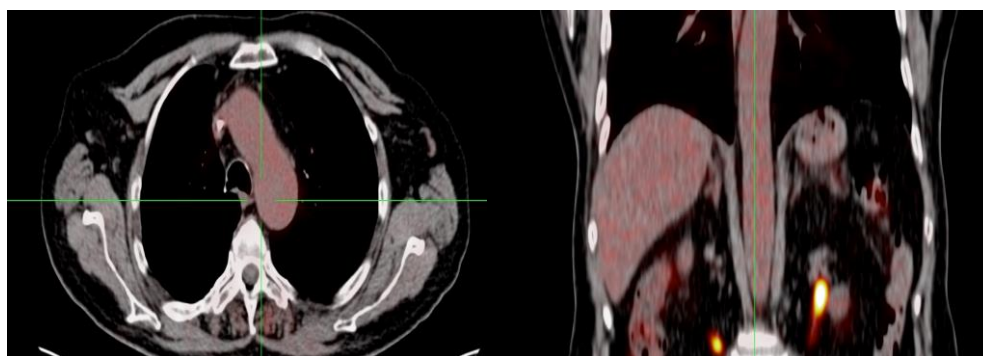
67 years old male patient with diagnosis of adenoid cystic carcinoma of the lung and left submandibular gland. The patient was referred for treatment response evaluation and the PET/CT images showed severe abdominal vasculitis as well as muscular involvement.
